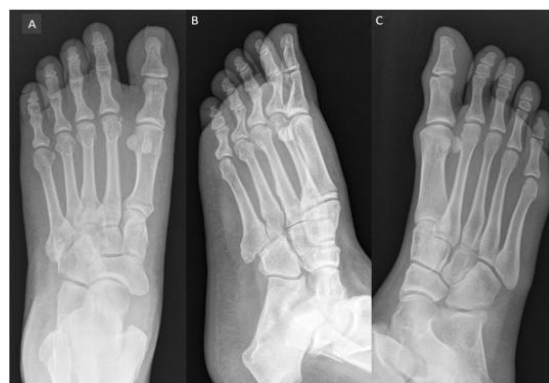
Normal foot radiographs anterior-posterior view (A) and oblique view (B) showing triphalangeal fifth toe. Oblique view of another foot showing biphalangeal fifth toe (C).
